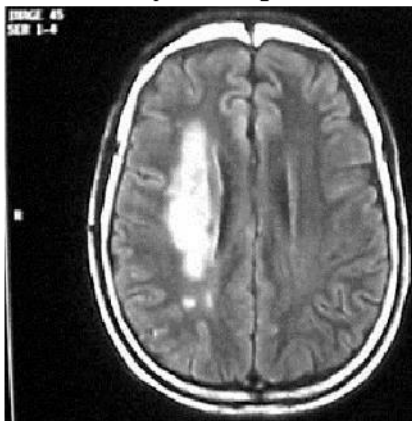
Input MRI image.
